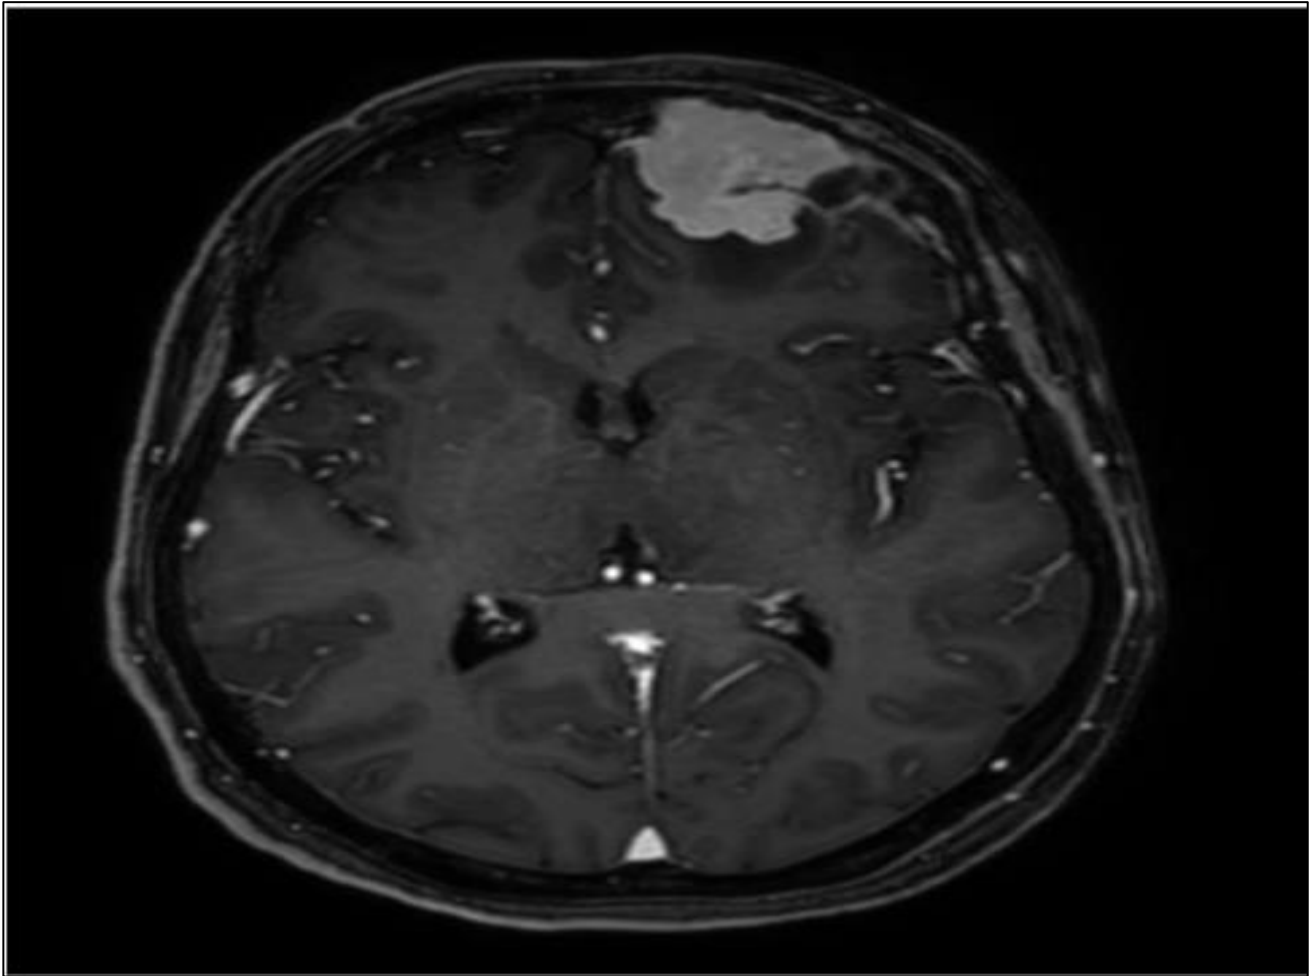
Axial Section of a Brain MRI after Injection of Gadolinium Showing a Left Orbital Roof Lesion with Contiguous Extradural Extension into the Ipsilateral Basifrontal Region
